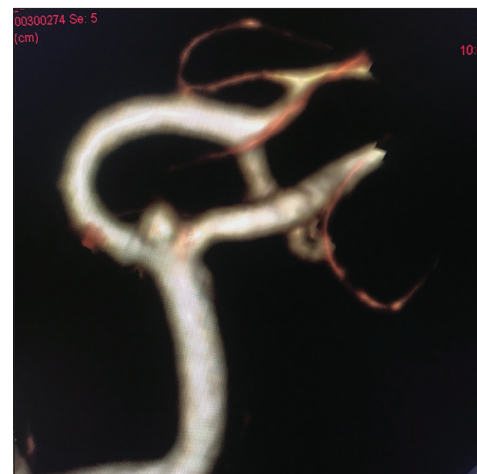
Computed tomography angiogram showing middle cerebral artery bifurcation aneurysm
